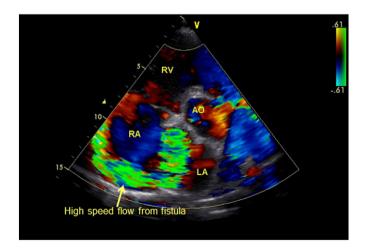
Same patient as in Fig. 1. Color Doppler signal on parasternal short axis view showed the high speed flow from the right coronary fistula draining into right atrium (yellow arrow) (RV: right ventricle; RA: right atrium; LA: left atrium; AO: ascending aorta).
